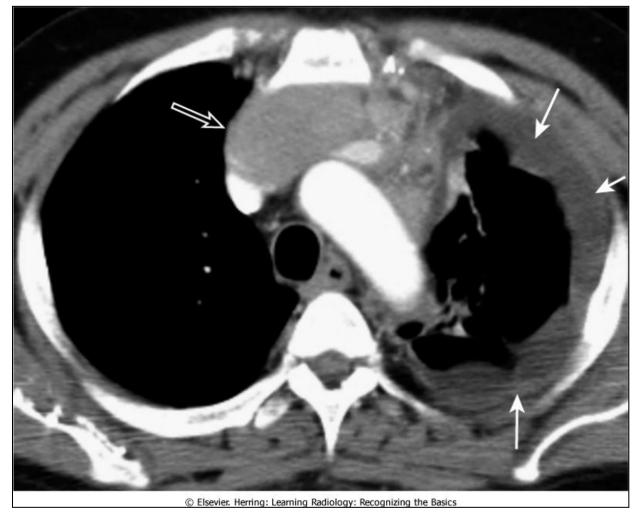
CT of anterior mediastinal adenopathy in Hodgkin's disease. On CT, lymphomas will produce multiple, lobulated soft tissue masses or a large soft tissue mass from lymph node aggregation (open white arrow). The mass is usually homogeneous in density, as in this case, but may be heterogeneous when the nodes achieve a sufficient size to undergo necrosis (areas of low attenuation, i.e., blacker) or hemorrhage (areas of high attenuation, i.e., whiter). There is a malignant pleural effusion present in this patient (closed white arrows) as evidenced by the nodular and irregular appearance of the pleural disease.
